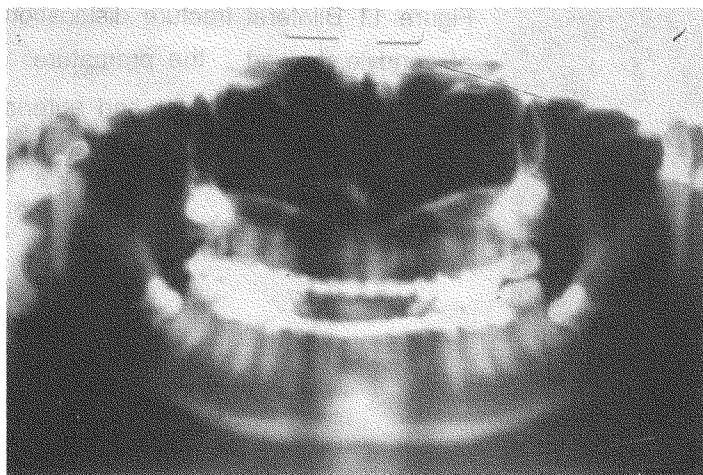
Post-op x-ray showed the fixed bilateral condylar fracture.
